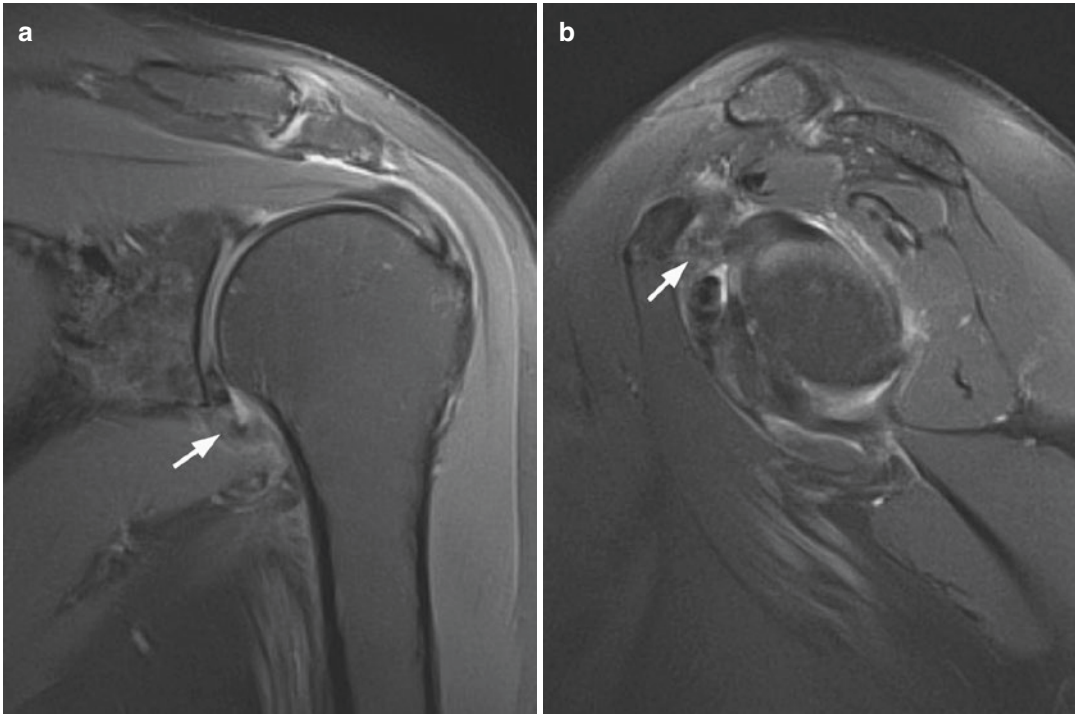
Adhesive capsulitis. A coronal T2-weighted fs FSE image (a) with edema in and around the capsule in the axillary recess (arrow, a). Sagittal oblique T2-weighted
